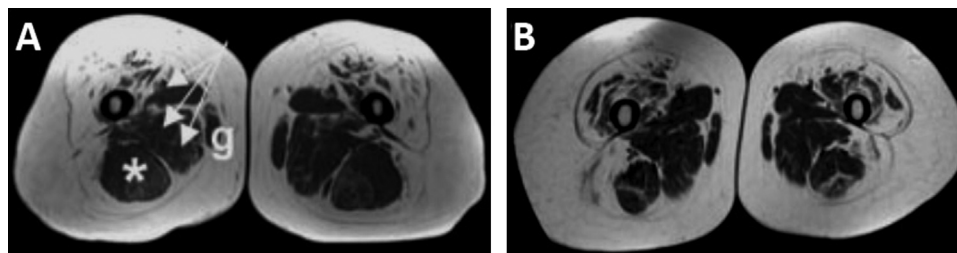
T1-weighted axial muscle magnetic resonance images of the lower limb in individuals with spinal muscular atrophy due to mutations in BICD2. Note the variable fatty replacement of the muscles of the anterolateral thigh but relative sparing with or without relative hypertrophy of the semitendinosus muscle (white asterisk, A), the medially placed adductor muscles (adductor longus, brevis and magnus; white arrows in A), and gracilis ('g' in A).
